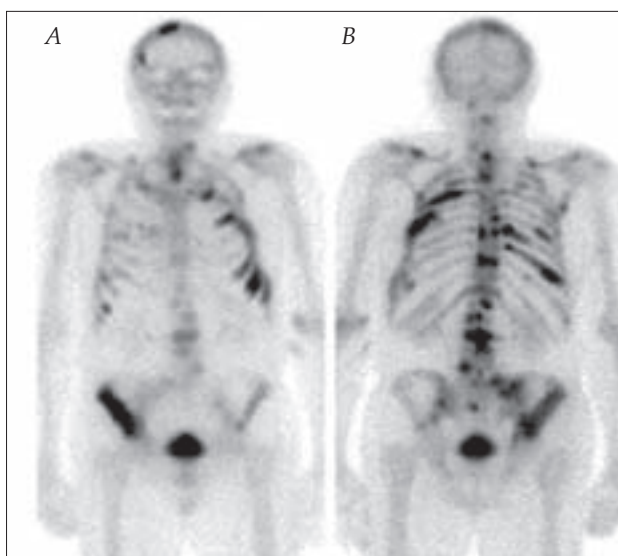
Radionuclide bone scintigraphy showing widespread metastasis in a patient with prostate cancer: (A) anterior view; (B) posterior view.
